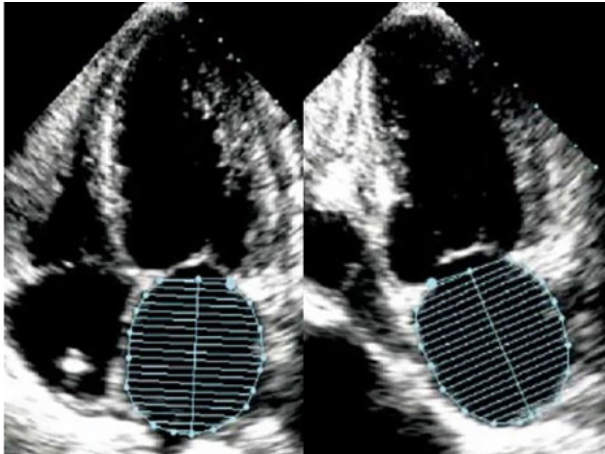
Prognostic value of left atrial volume in heart failure. These images show the standard echocardiographic method to measure bi-plane left atrial volume which is then indexed to the body surface area.
